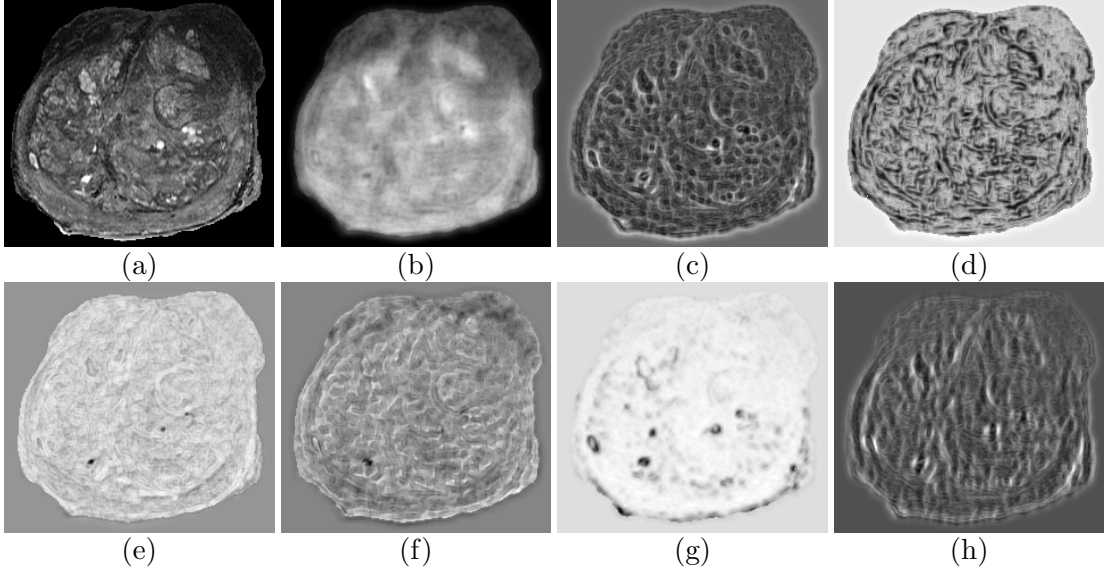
MRI intensity image (a) and corresponding independent component feature images obtained via ICA (b)-(h) of feature images (not shown). Maximal statistical independence between independent components is maximized to facilitate naïve combination in Bayes' rule.
